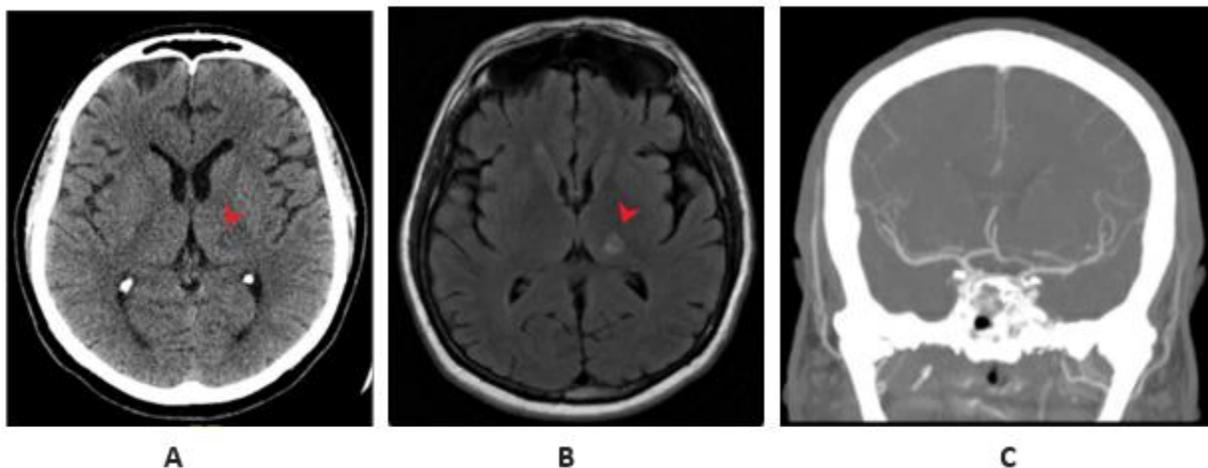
(A) Brain CT showing focal well-rounded hypodensity within the left basal ganglia (white arrow). (B) MRI of the brain showing late acute to early subacute left thalamic infarct without hemorrhagic conversion (white arrow). (C) CT angiogram of the head showing normal intracranial imaging.
